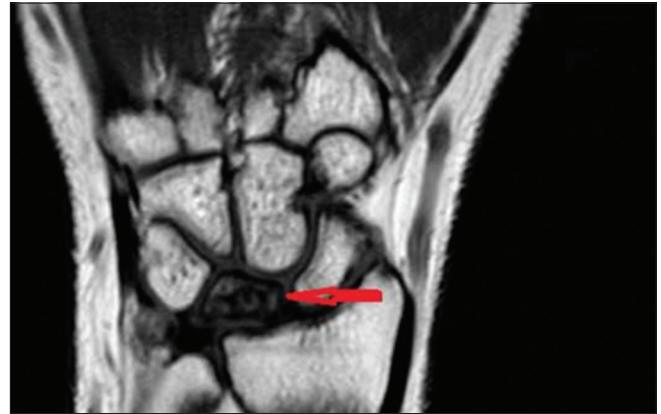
MR image showing low T1 signal of the lunate
